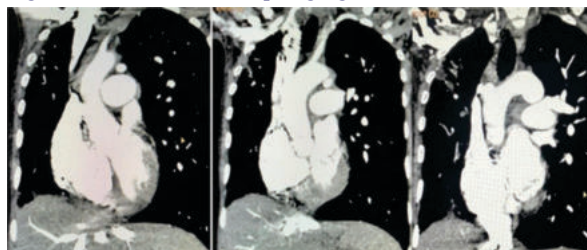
(B): CT-Pulmonary Angiogram
